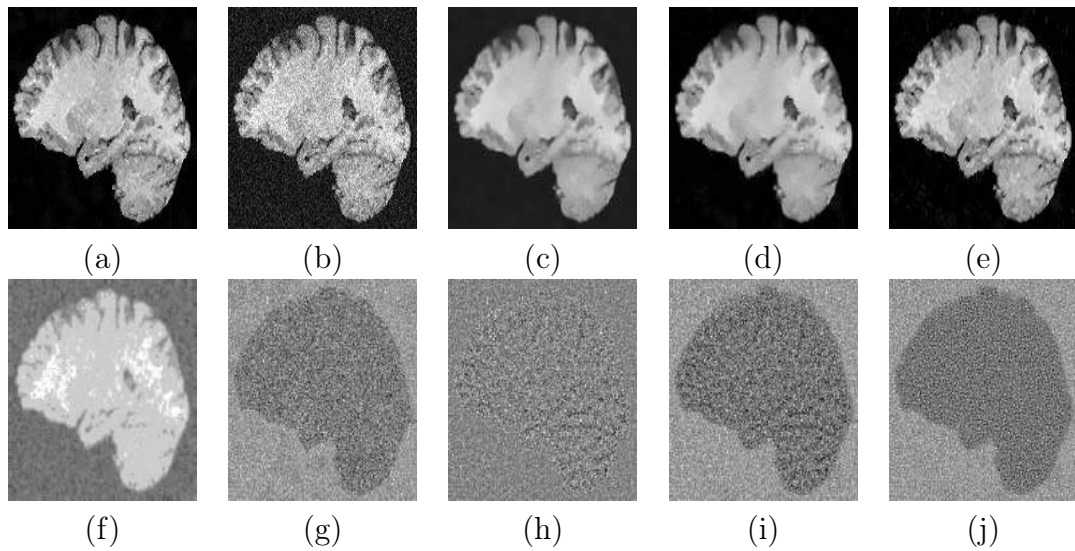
Real MR image 3: (a) Noise-free image, (b) noisy image (noise level = 9%), (c) NLM-output [46], (d) UNLM-output [42], (e) PCNNNI_IUNLM output, (f) Time Matrix, (g) actual noise, (h) residual of NLM, (i) residual of UNLM, (j) residual of PCNNNI_IUNLM.
